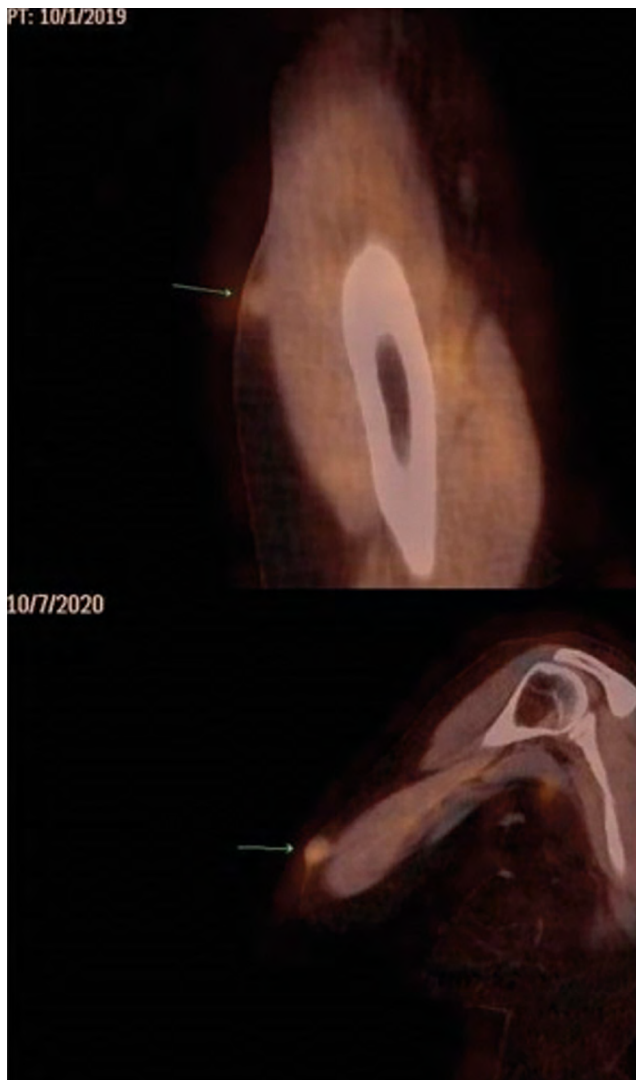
A patient with a non-symptomatic in-transit lesion detected as malignant on [^{18}F]FDG PET/CT (A). It was not found in conventional studies and the patient came for a follow-up scan 12 months later with the clinically evident in-transit lesion (B)
